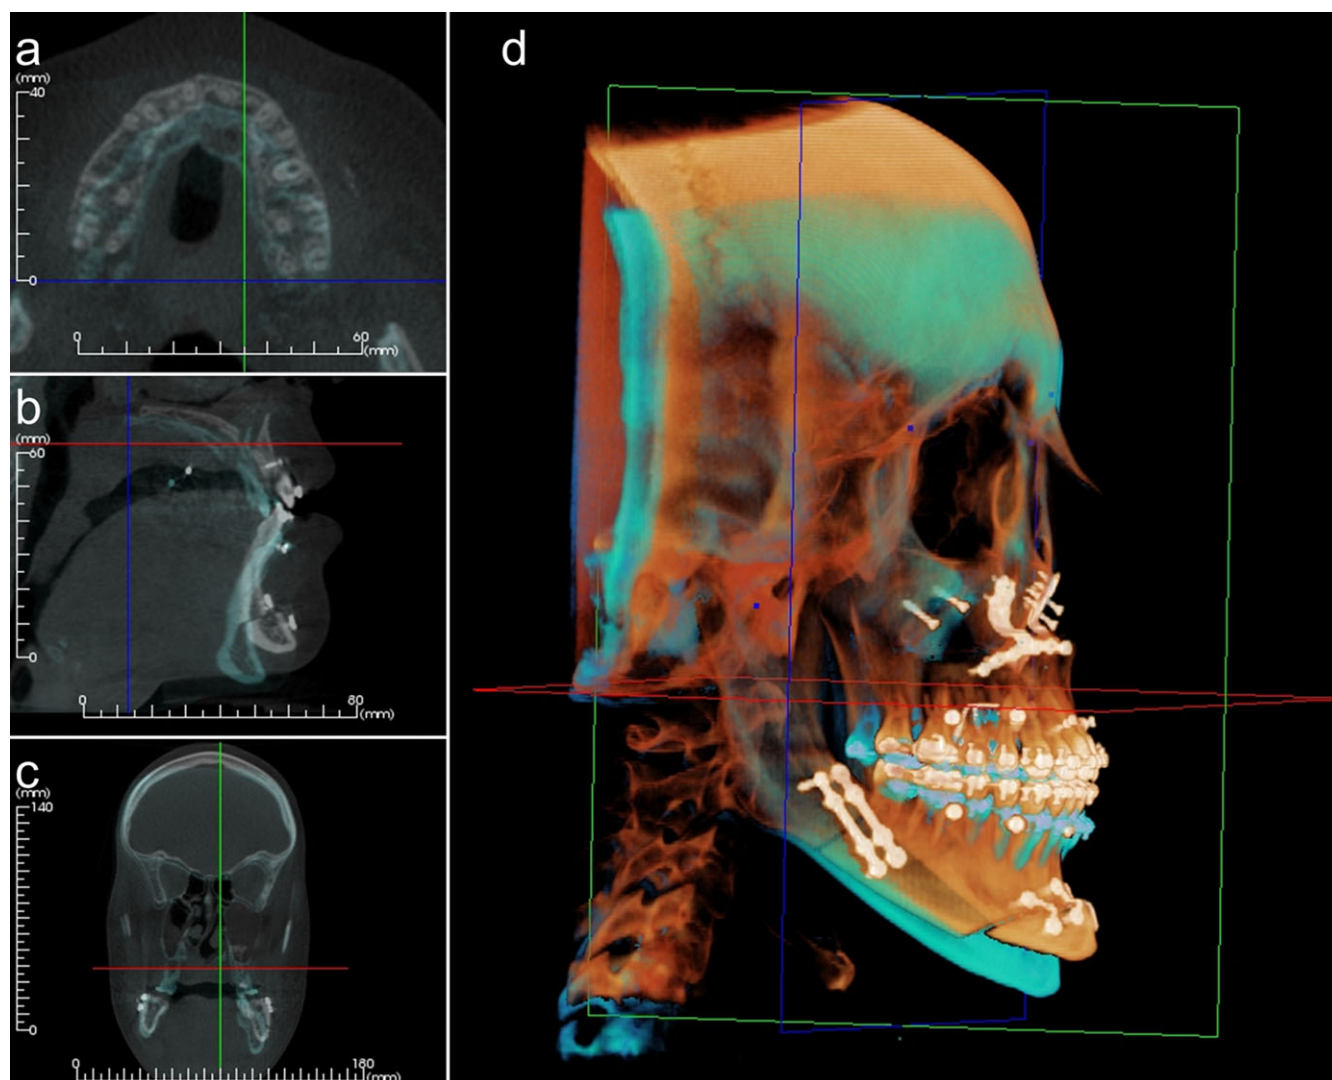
Screen shot of computer program allowing superimposition of initial CBCT data (blue) with post orthognathic treatment CBCT data (orange). Superimposition of reference anatomic landmarks in axial (a), sagittal (b) and coronal (c) reference planes provides a 3D volumetric representation (D.). (Images courtesy of Anatomage, San Jose, California, USA).
